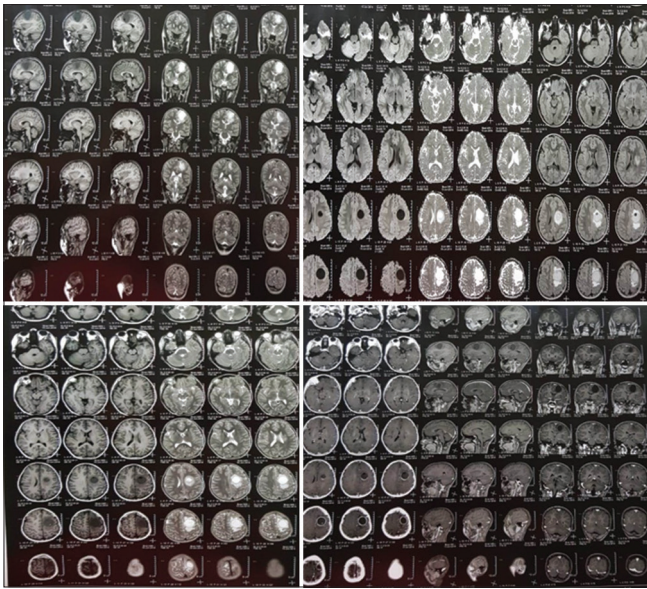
Preoperative MRI of a 12-year-old male child presented with epileptic seizures.
